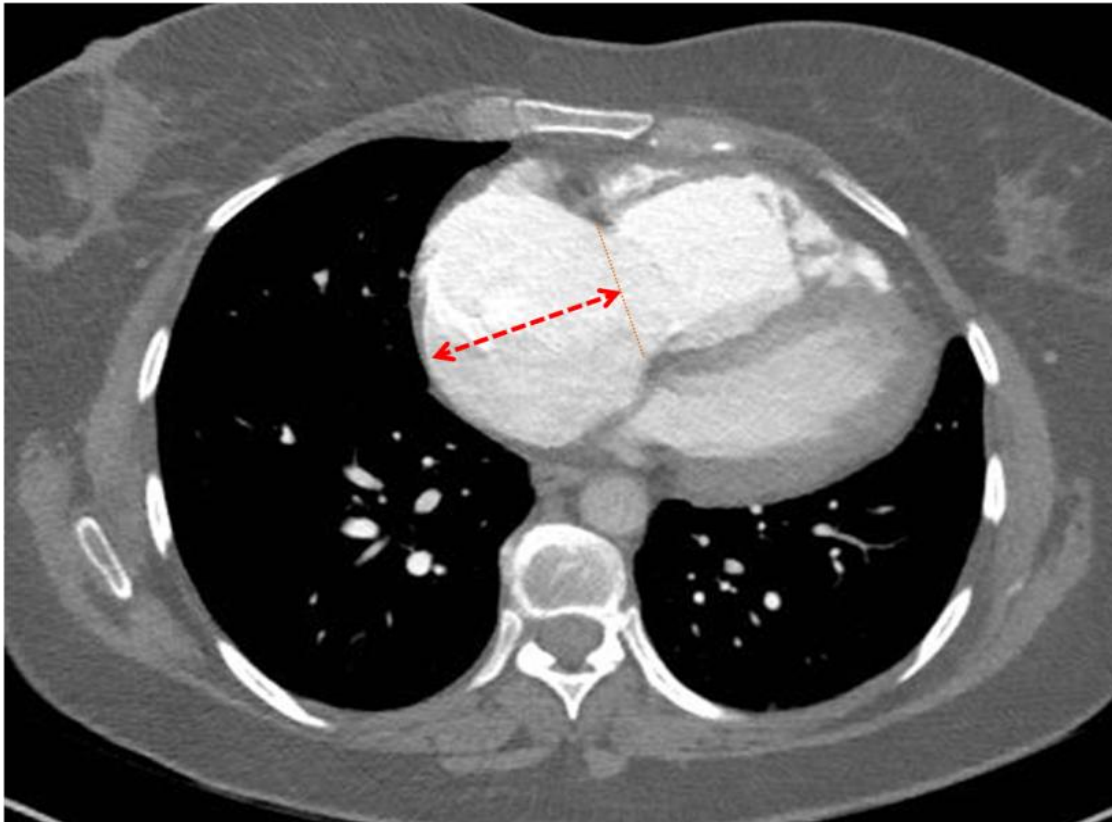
For assessing the right atrial size on CT, right atrial length was measured from the centre of tricuspid annulus to the superior right atrial
